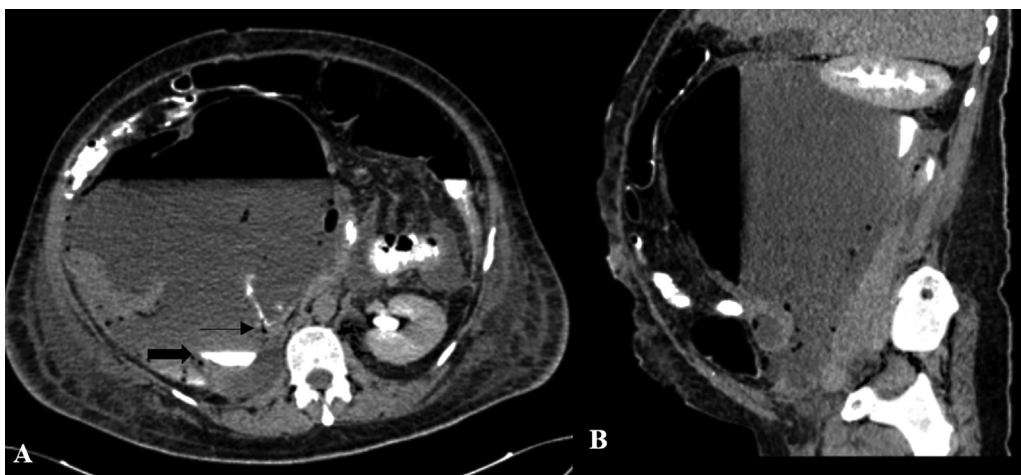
(A) Axial contrast-enhanced computed tomography (CT) of the abdomen in 15-minute delayed phase in a 51-year-old woman with a history of abdominal surgery shows a large well-defined collection in the perinephric space. There is contrast spurt from the right ureter (*thin arrow* in A) and subsequent contrast layering in collection (*arrow* in A) resulting in the formation of *urinoma* secondary to ureteric injury. (B) Sagittal reformatted CT image shows cranial displacement of the right kidney.
